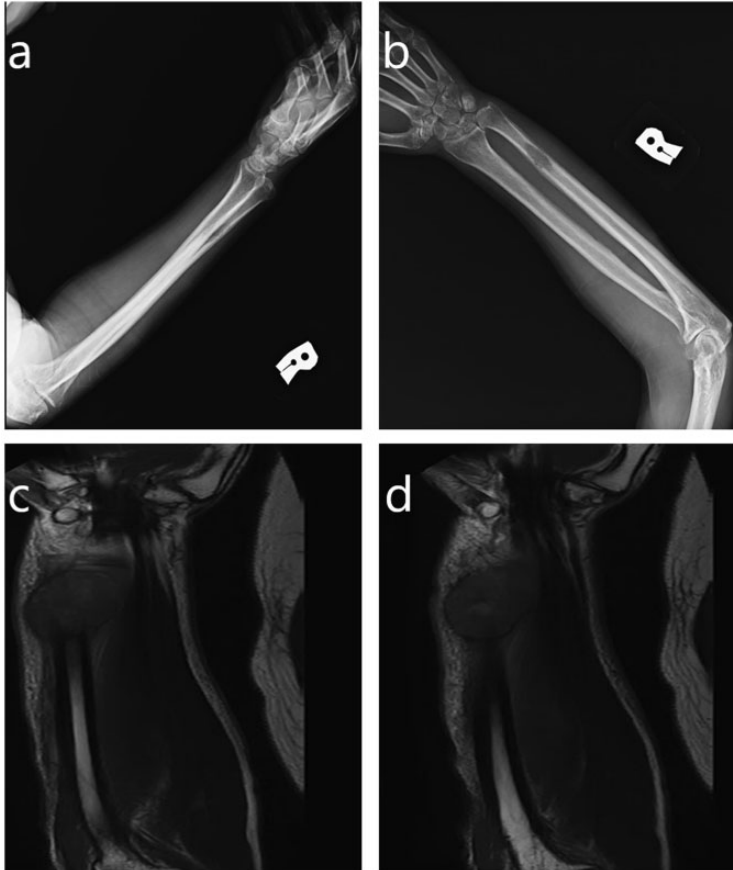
(a, b) Radiographs and (c, d) T2-weighted magnetic resonance imaging. An osteolytic lesion with a central heterogeneous extraosseous component was noted over the right distal ulna.
